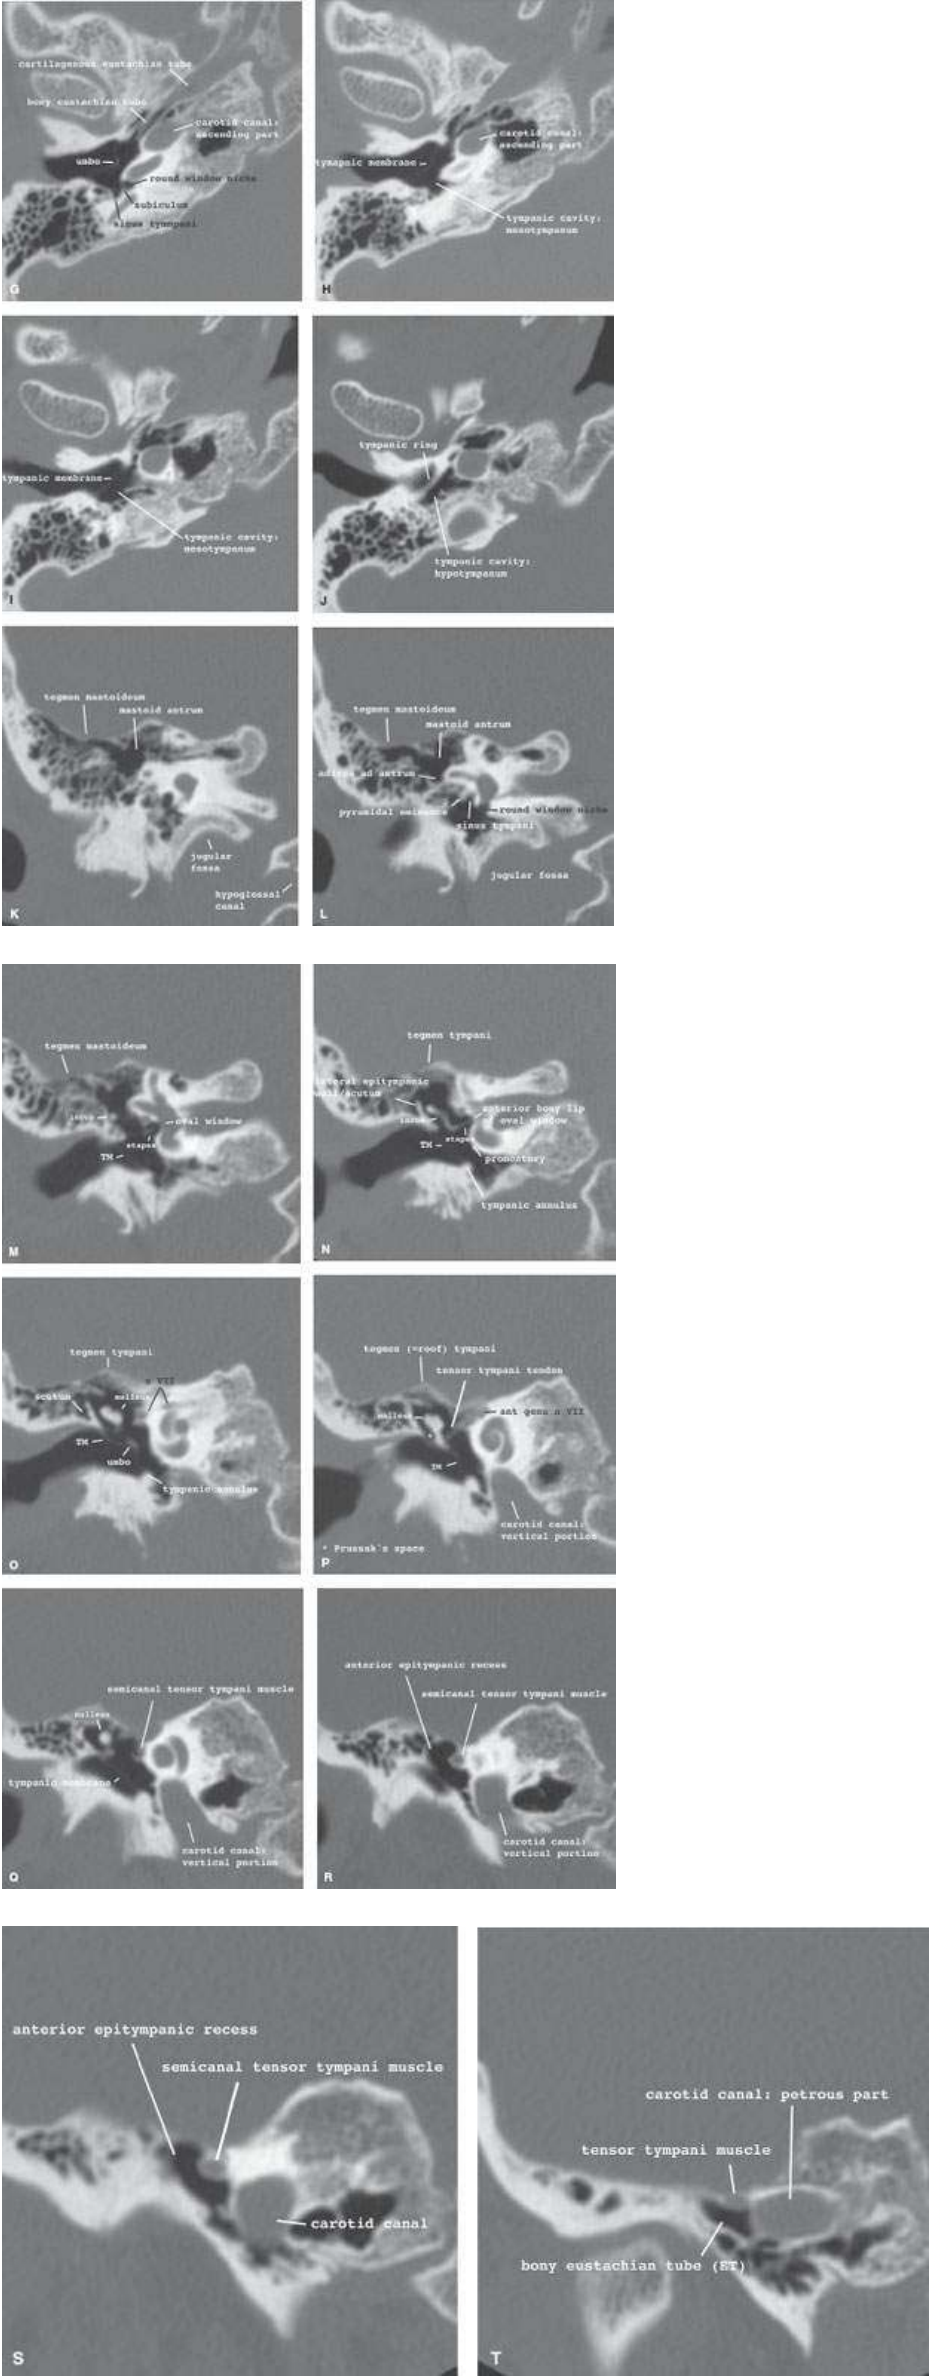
Normal anatomy of the middle ear. Axial (A–J) and coronal (K–T) computed tomography images.
